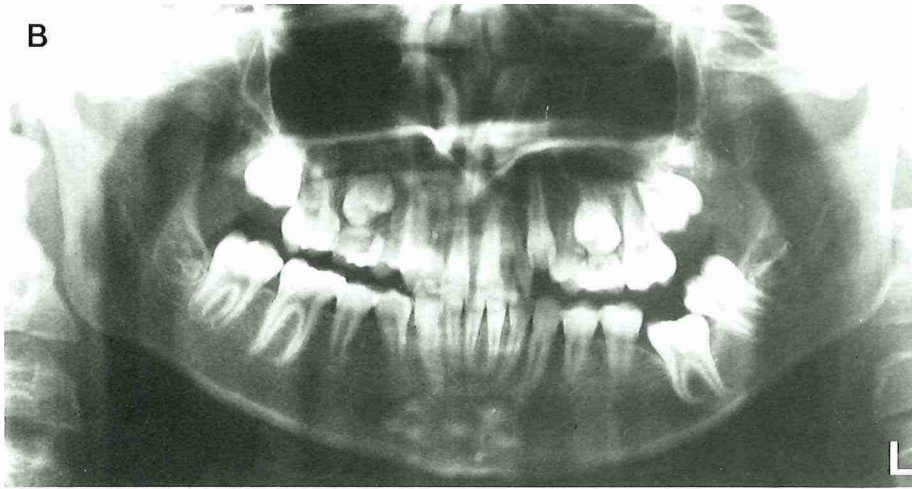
A (see page 50) Orthopantomogram of a 10-year-old girl with secondary retention of the mandibular left first molar. B Orthopantomogram of the same patient after 1 year. The infraocclusion had increased. C Orthopantomogram of the same patient after 3 years. The maxillary left second molar was now secondarily retained. The diastema in the mandible, due to the removal of the secondarily retained left first molar was closed by means of orthodontic treatment.
